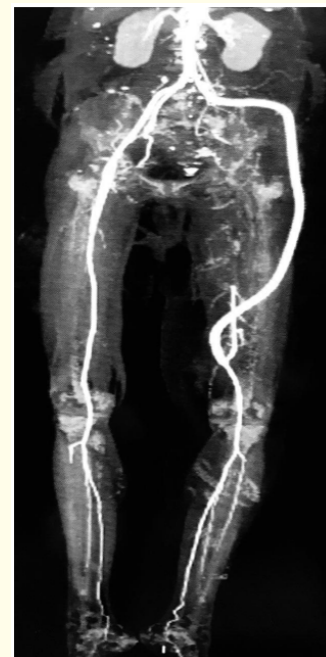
CTA done after the initial presentation and revealed left iliac and femoral total occlusion, calcifications and collateralization.
